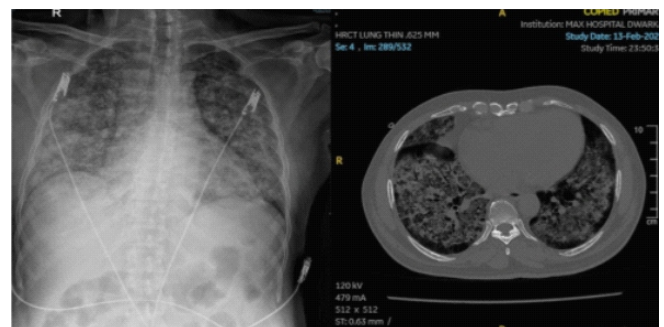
Chest X-ray showing bilateral diffuse patchy airspace opacities suggestive of alveolar consolidation (Left), HRCT chest showing diffuse ground-glass opacities with superimposed interlobular septal thickening and intralobular lines consistent with a “crazy paving” pattern (Right).
